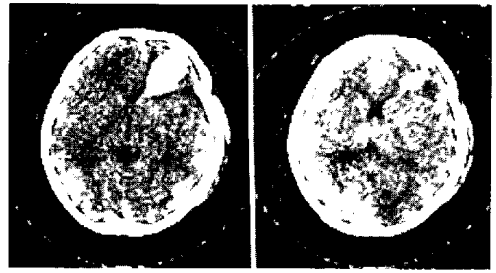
Intracerebral hematoma. 12-year-old male. CT was performed 3 days after trauma. A characteristic wedge-shaped high density area is seen in the right frontal area.
